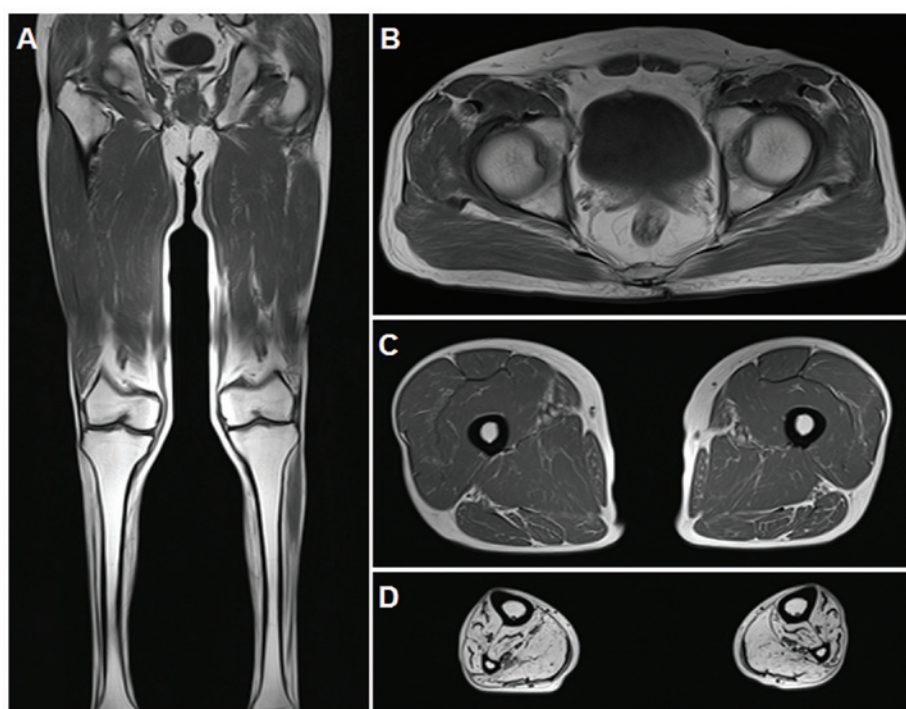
Lower extremity magnetic resonance image of the proband (III-13). (A) T1-weighted coronal image of the lower extremities indicated markedly hyperintense signal changes and atrophies in all muscles of the lower leg, whereas all muscles of the thigh and hip were normal. (B) T1-weighted axial images of the hip revealed normal characteristics. (C) At the thigh level, no muscles revealed fatty changes. (D) T1-weighted axial images of the calf indicated that almost all muscles demonstrated markedly diffuse atrophies and fatty hyperintense signal changes.
